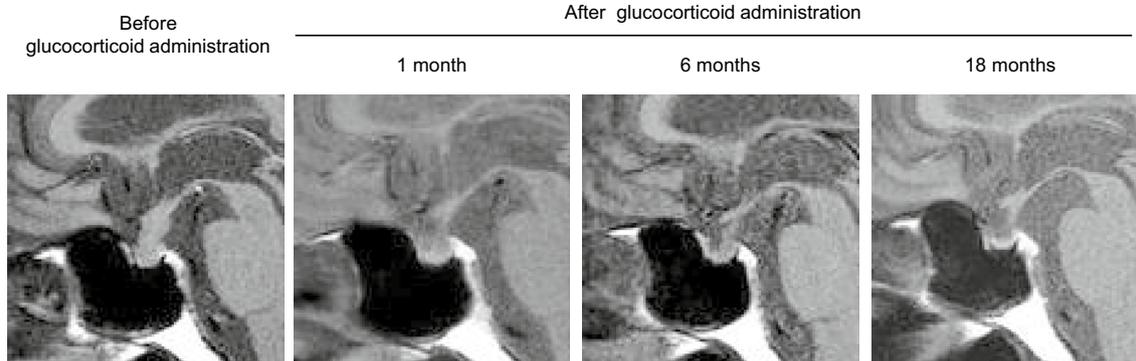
Changes in the pituitary MRI findings of case 1 that showed a typical IgG4-related hypophysitis. Enlargement of the pituitary gland and thickened pituitary stalk shrank and became empty sella during the glucocorticoid treatment
